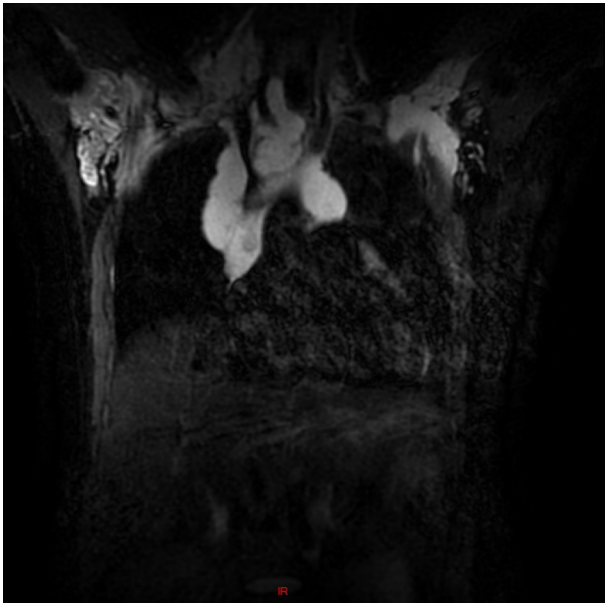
Magnetic resonance imaging of the breast, T2-weighted image in coronal plane.
